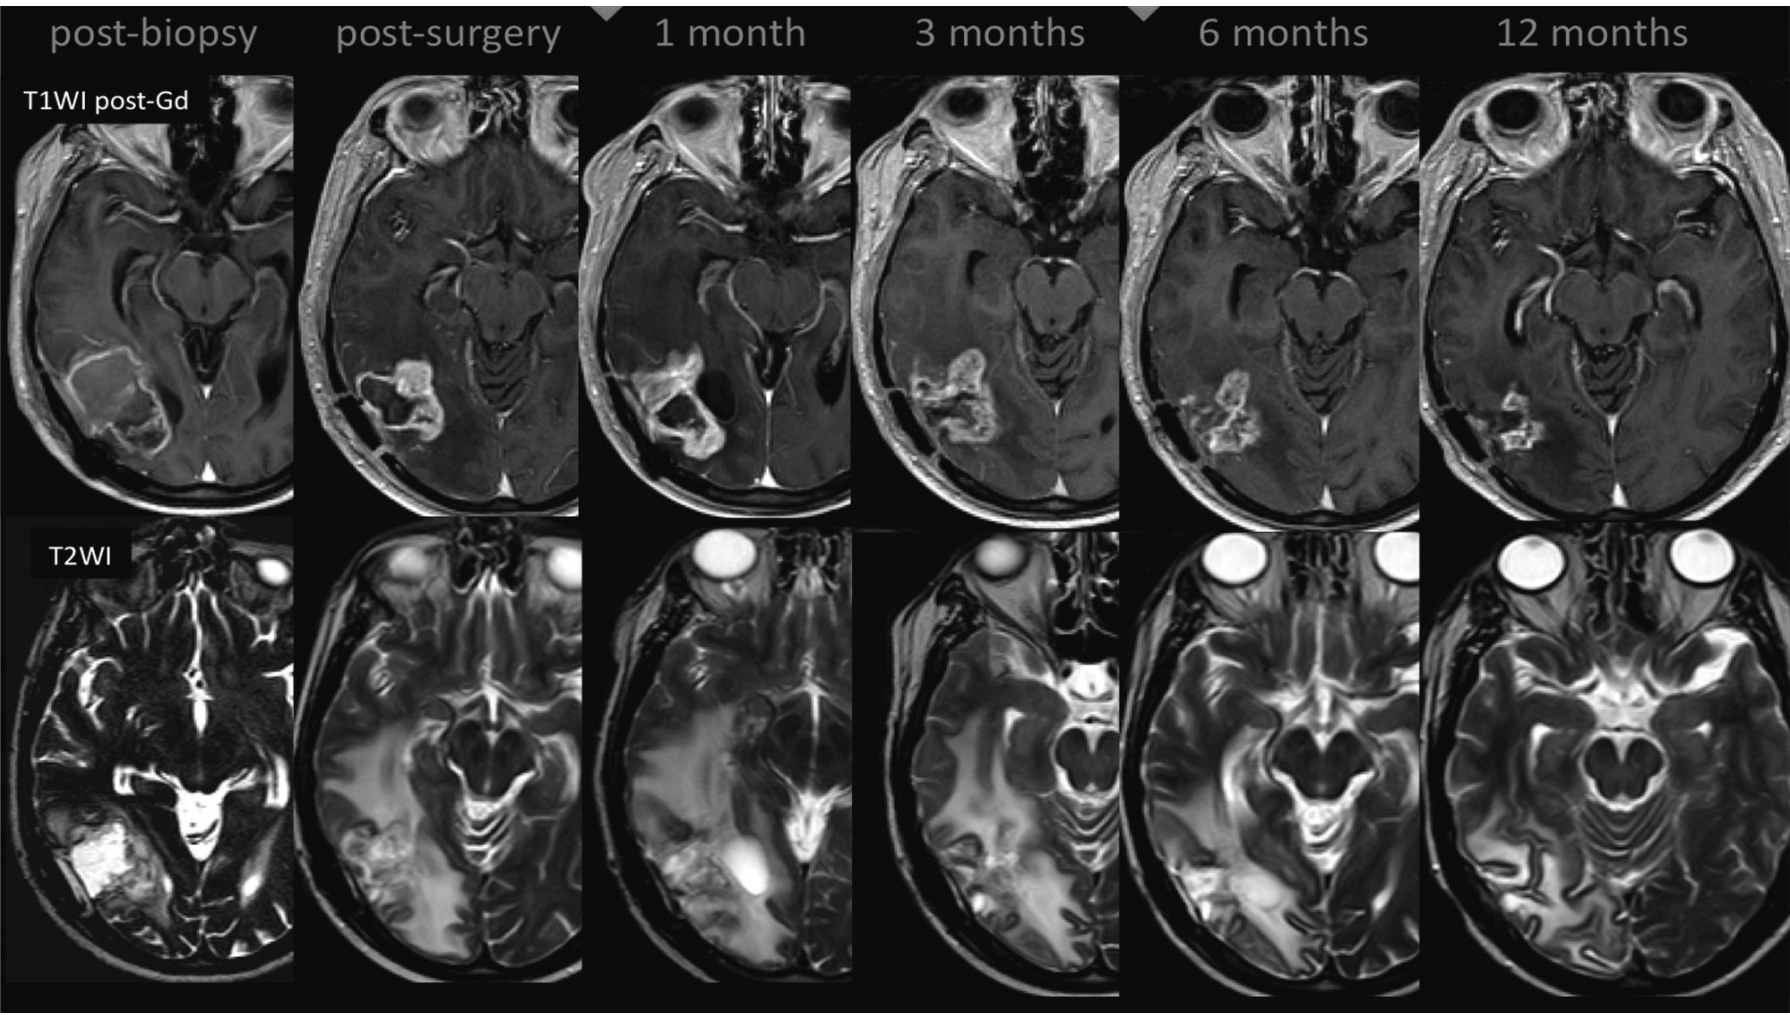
Pseudoprogression in a 59-year-old man with GBM. An MR image obtained 1 month after CCRT demonstrates an expansion of the right temporal lesion. Reductions in both the enhancing lesion (T1WI) and the surrounding abnormal hyperintense area (T2WI) were seen in the follow-up images.<sup>6</sup>
